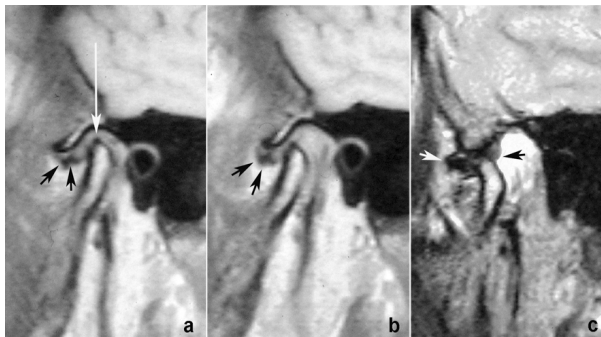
Magnetic resonance images of the left temporomandibular joint in the position of maximum intercuspitation (a), forced anterior position (b) and open mouth position (c). Note: anterior displaced disc with reduction (short arrows) and degenerative changes of anterior part of cortical condylar head (long arrow).
